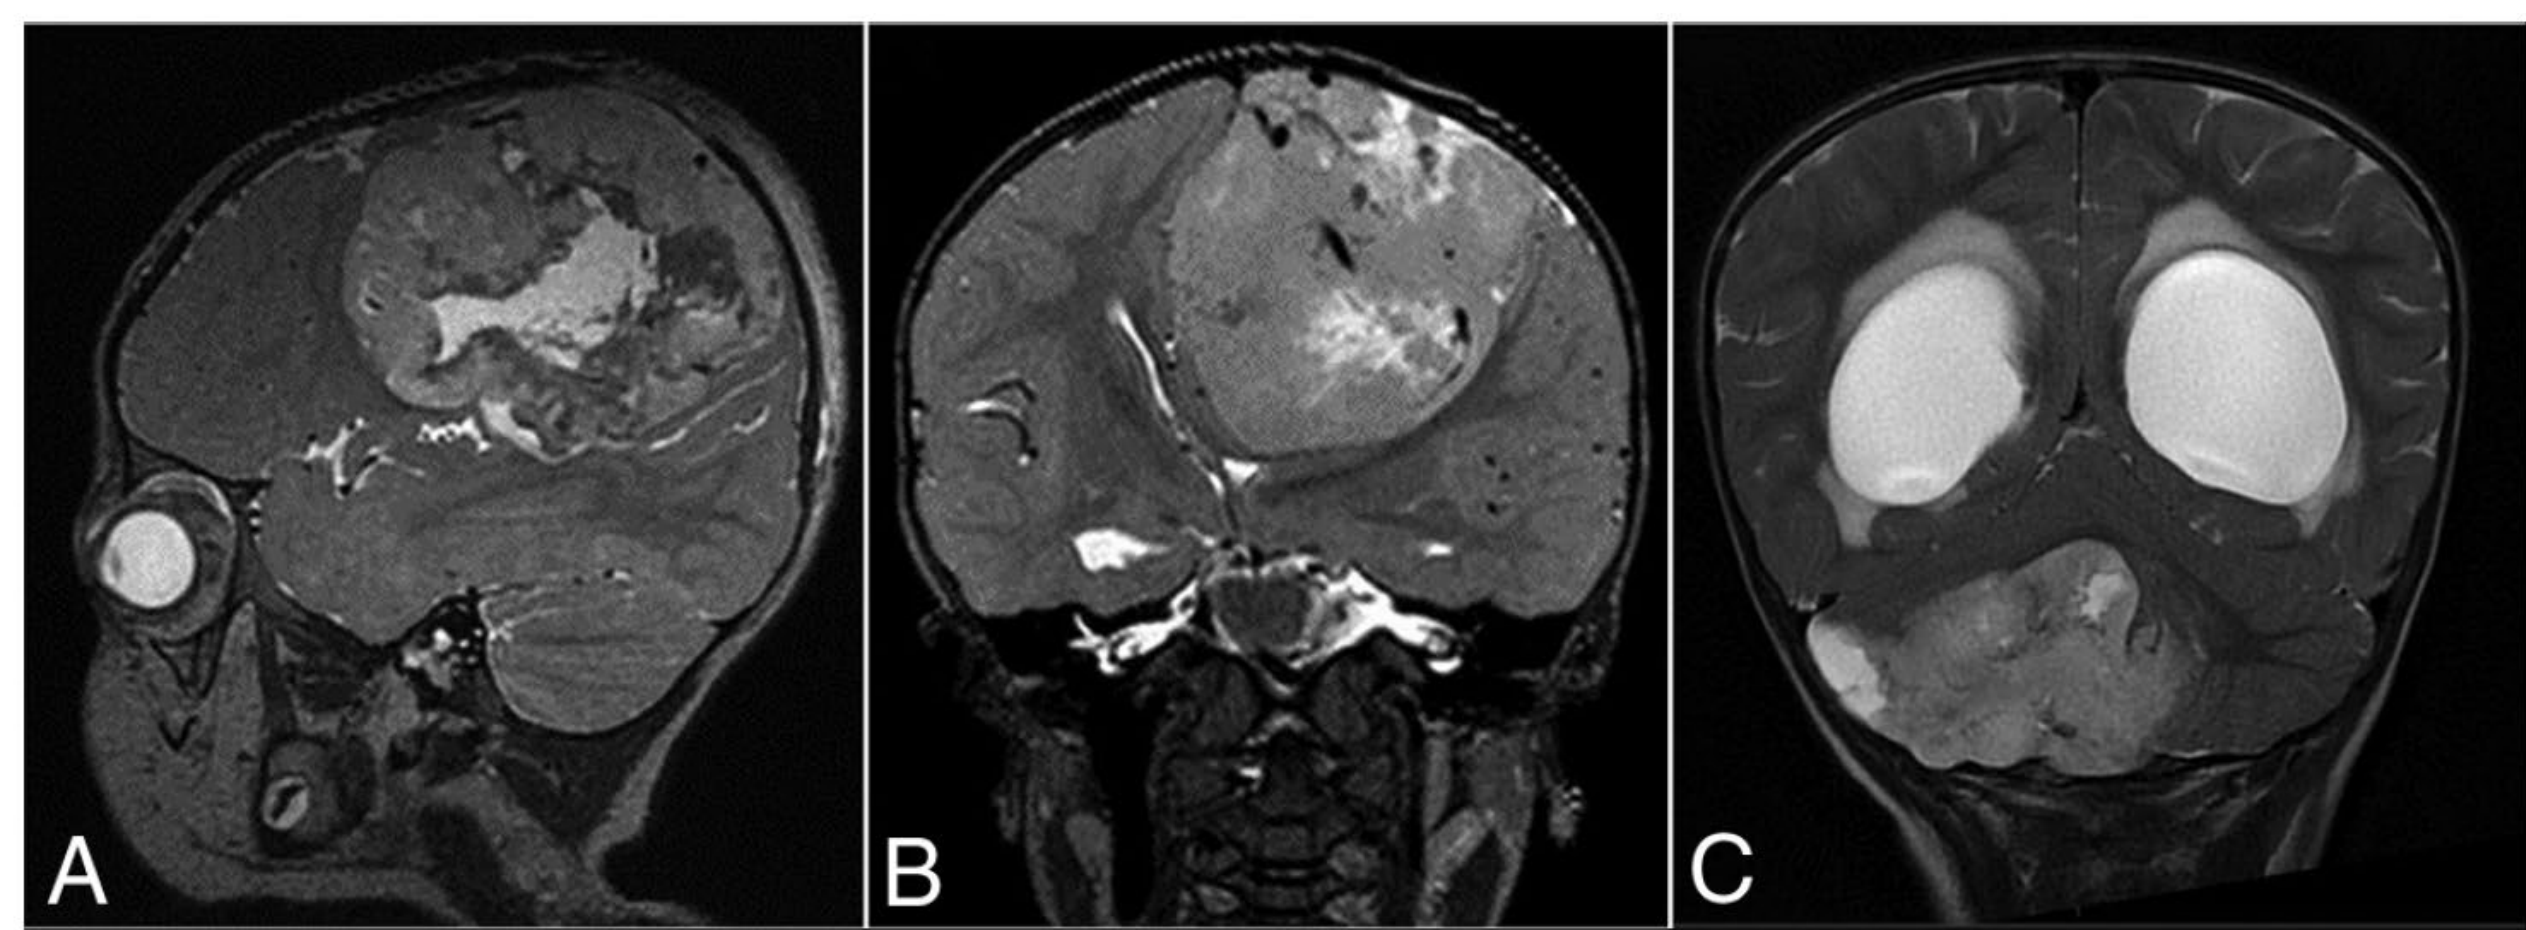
T2-weighted MR images showing large masses located supratentorially (A and B) and infratentorially (C).
